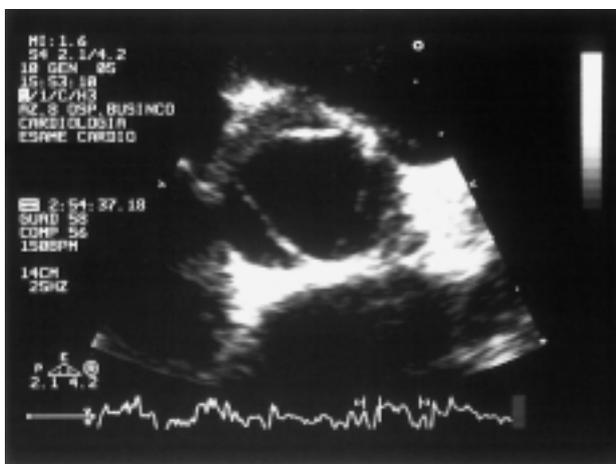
Two-dimensional echocardiography performed 18 months after the resection of the aortic mass showing a normal aspect of the aortic valve without tumor recurrence.
